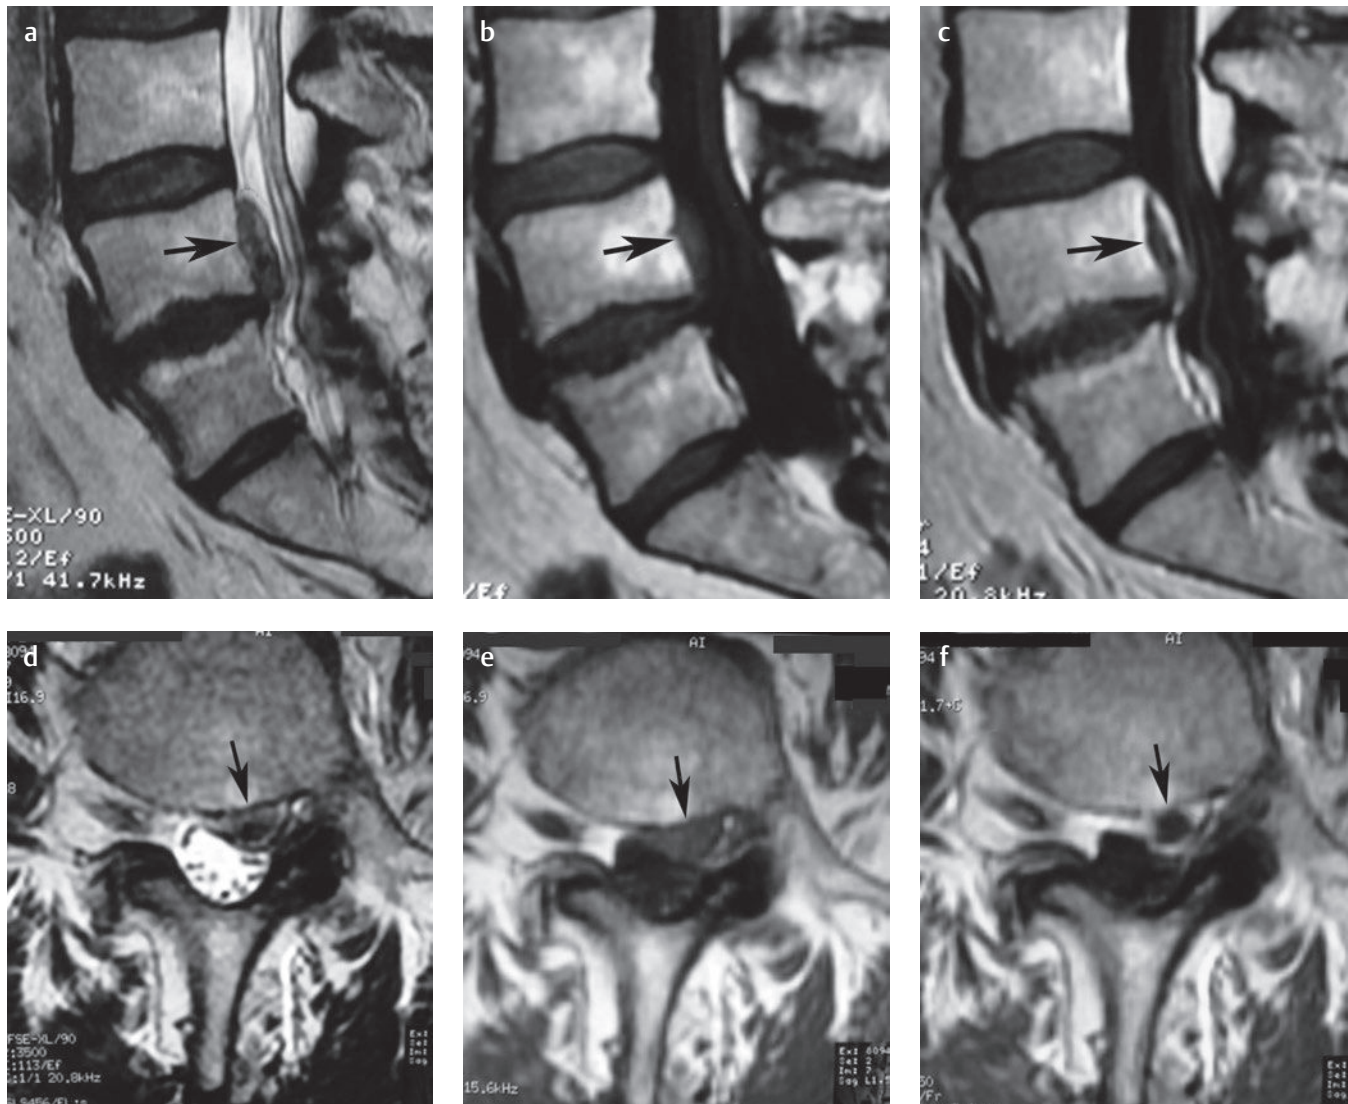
Recurrent lumbar disc extrusion. (a) Sagittal T2-weighted, (b) T1-weighted, and (c) postgadolinium T1-weighted images in a patient with a history of previous L4-L5 discectomy show a large disc extrusion (arrow on each) that has migrated proximally and is located behind the L4 vertebral body. Note that the disc is difficult to see on (b) the T1-weighted image and shows peripheral enhancement on (c) the postgadolinium T1-weighted image. (d) Axial T2-weighted, (e) T1-weighted, and (f) postgadolinium T1-weighted images at the L4-L5 level show the left paracentral extradural lesion (arrows on each) that appears to be disc material on (d) the T2-weighted image and shows peripheral enhancement on (f) the postgadolinium T1-weighted image compared with (e) the pregadolinium T1-weighted image.[†]
